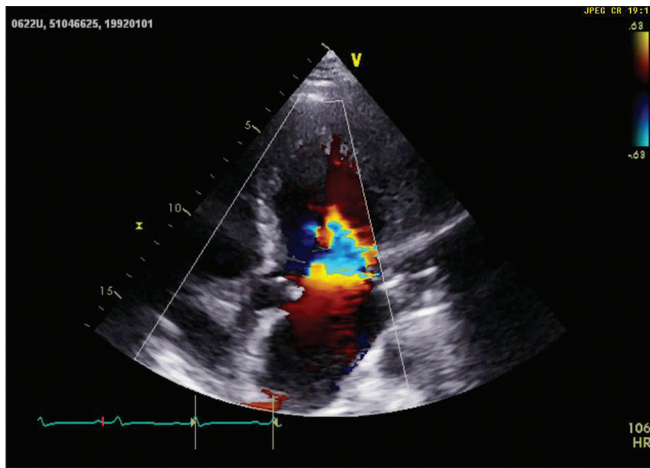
Color Doppler demonstrating blood flow directly connecting ventricular cavity and deep recesses in a patient with isolated left ventricular noncompaction
